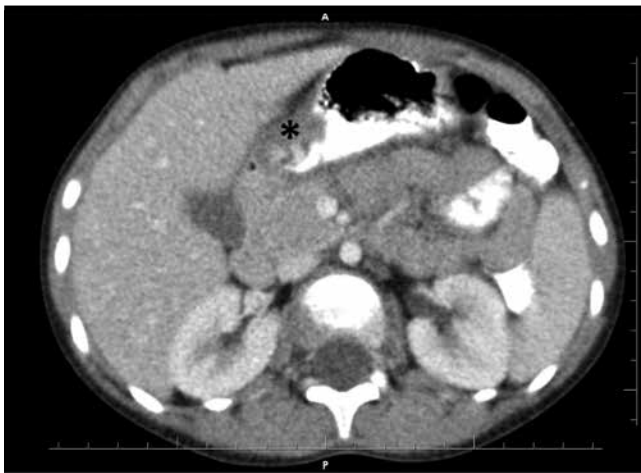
Preoperative computed tomography: Soft tissue thickening at the anterior wall of stomach and pylorus (asterisk); the widest segment was 19×12 mm
